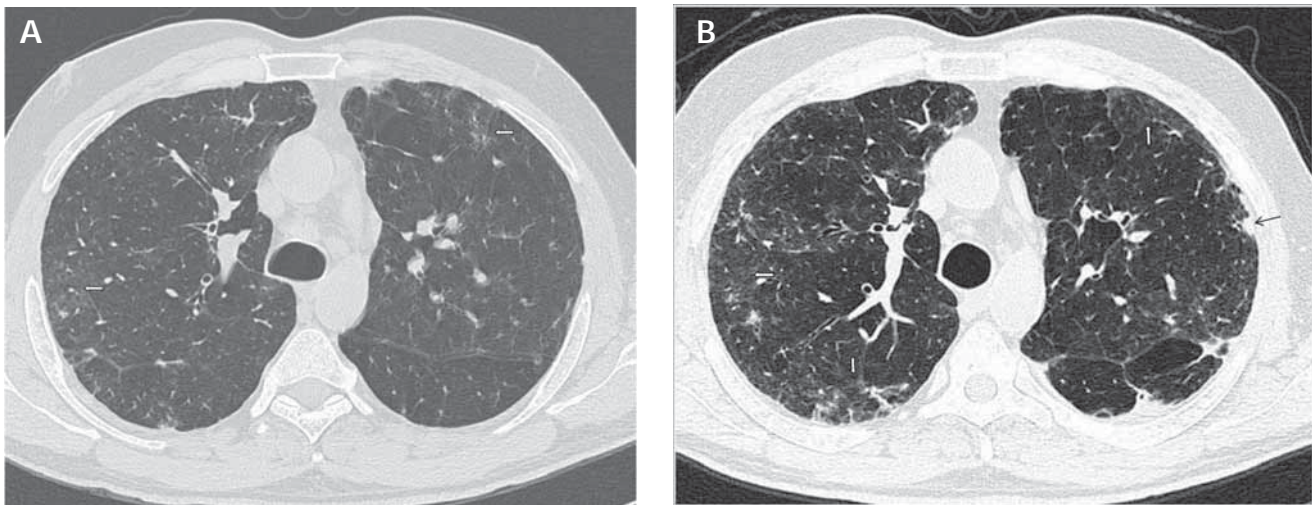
A, HRCT scan of the same patient at a lower level on the upper lobes shows fine reticular opacities and focal peripheral ground-glass areas (thick arrows) in the year 2005. B, Follow-up HRCT scan in the year 2008 showing the development of a subpleural nodule (thin arrow), and progression in areas of ground-glass opacity and reticulation (thick arrows). HRCT indicates high-resolution computed tomography.
